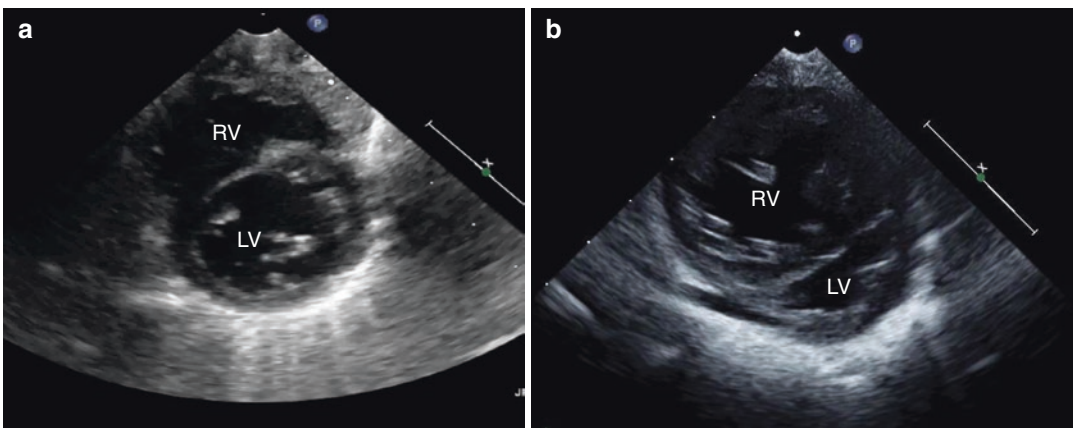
Assessment of septal flattening in parasternal short axis view. (a) Normal rounded septum consistent with normal RV pressures, (b) Flattened septum, consistent with elevated pulmonary pressures
